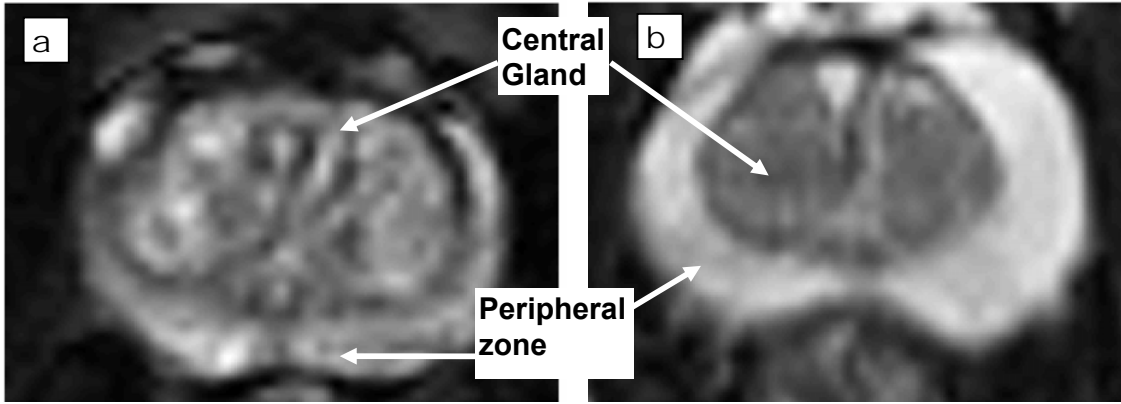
The central axial slice through T2 Fat-suppressed MR images of the prostate showing: (a) the granular inhomogeneous appearance characteristic of the central gland and the compressed peripheral zone associated with glandular (non-stromal) BPH, and (b) the more homogeneous appearance of the central gland and larger peripheral zone in stromal BPH.
